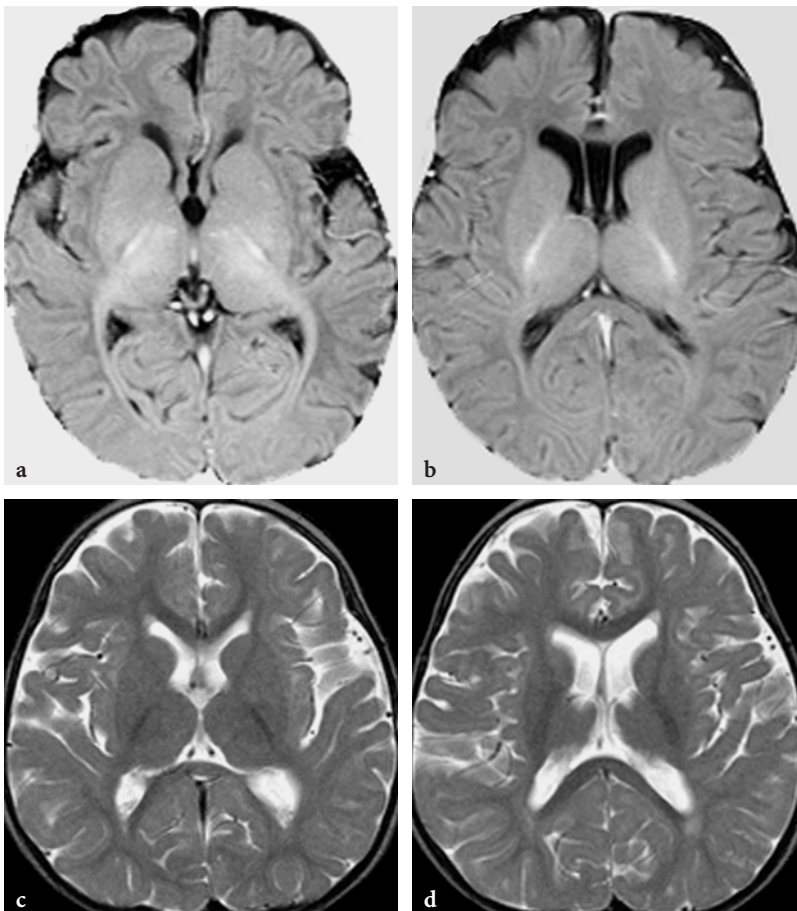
MR imaging findings in 3-methylcrotonyl-coenzyme A carboxylase deficiency. a, b Axial T1-weighted inversion recovery images in a 3-month-old female patient. Only traces of myelin are seen within the optic radiations and splenium of corpus callosum, indicating delayed myelination. c, d Axial T2-weighted fast spin-echo images in a 15-month-old female patient. Mild fronto-temporal brain atrophy with some paucity of myelin (note the slight atrophy and faint hypersignal of splenium of corpus callosum)
